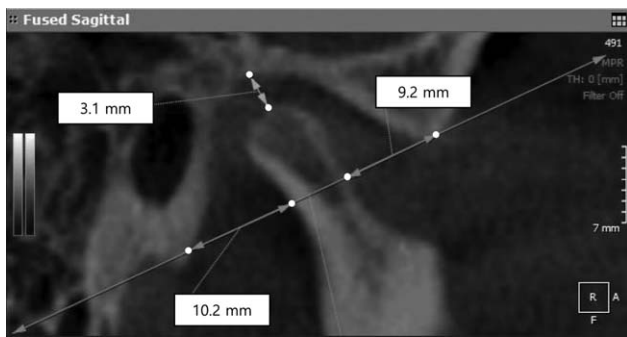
Measurement of condylar sagittal position on cone-beam computed tomography. Measuring the anterior and posterior distance between the eminence and condyle on the baseline between the orifice of the petrotympanic fissure and the lowest point of the articular eminence. The superior distance was measured from the perpendicular extent line to the baseline, across the highest point of the condyle.
